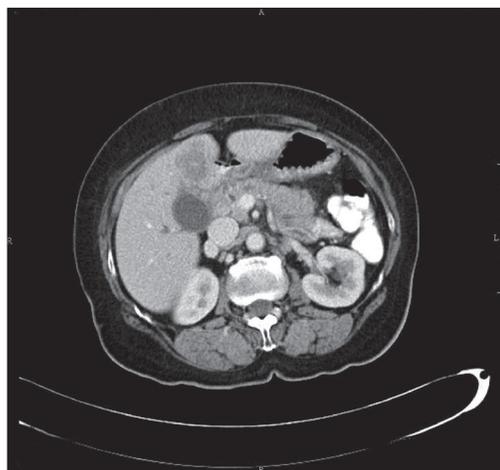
Computed tomography scan with gall bladder mass
